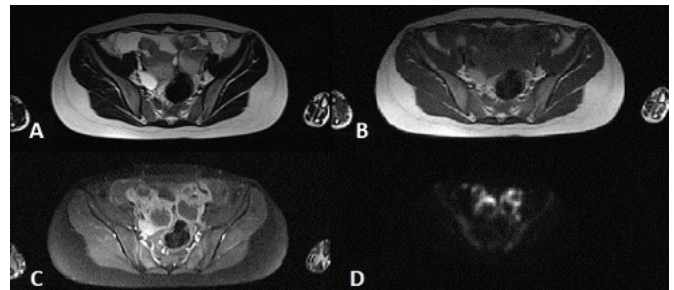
Bilateral ovarian mass lesions with cystic and soft tissue components. Peripheral enhancement after intravenous contrast injection and avid fluorodeoxyglucose (FDG) uptake in adnexal masses are seen. A) Axial pre-contrast T2-weighted (T2-W) sequence. B) Axial pre-contrast T1-W sequence. C) Axial post-contrast T1-W sequence. D) Fluoro-18 FDG-positron emission tomography imaging
